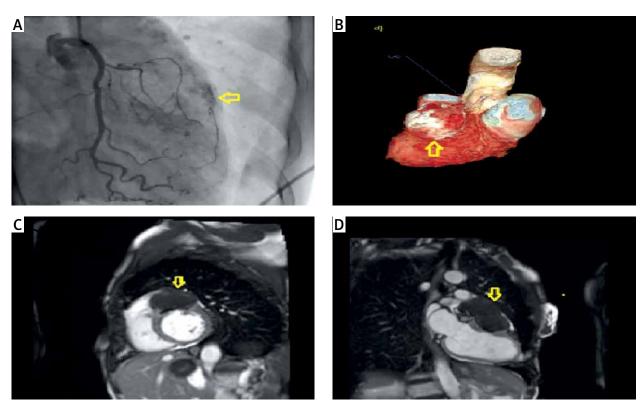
A – Left coronary angiography (right anterior oblique caudal view) demonstrating chronic total occlusion of the left anterior descending artery (LAD) and a mass next to the LAD (arrow). B - 3D computed tomography image showing the hydatid cyst (arrow). C, D – Magnetic resonance images of the hydatid cyst (arrows) in short axis
